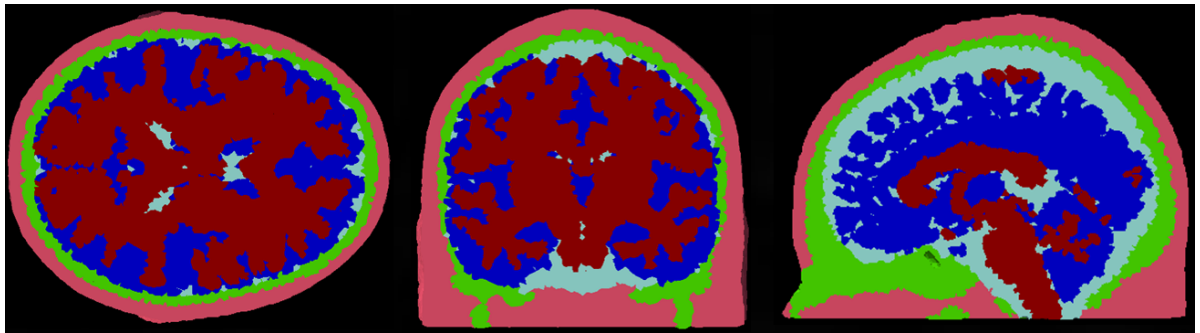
atlas-based segmentation of MRI images in Figure 4.1 based on the ICBM152 atlas in figure 4.5. The colour labels are the same as figure 4.5.
